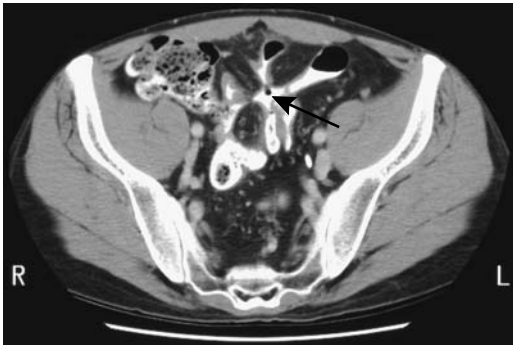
Multiple fistulas secondary to Crohn's disease. CT after oral contrast identifies matted loops of small bowel just superior to the bladder (arrow). Fistulas extend between small bowel, colon, and bladder. Other images identified gas within the bladder. (Courtesy of Patrick Fultz, M.D., University of Rochester.)
